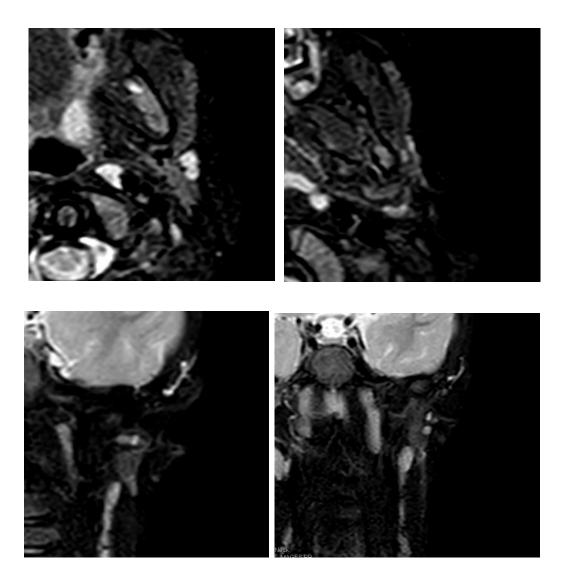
Axial STIR (top left and right) and coronal T2W TSE (bottom left and right) MRI images of patient B. MRI displays 5x10mm expansion (white arrow) lateral to the parotid extending across and deep to the parotid (white triangle). The distal segment lay immediately inferior and parallel to the left external acoustic canal.
